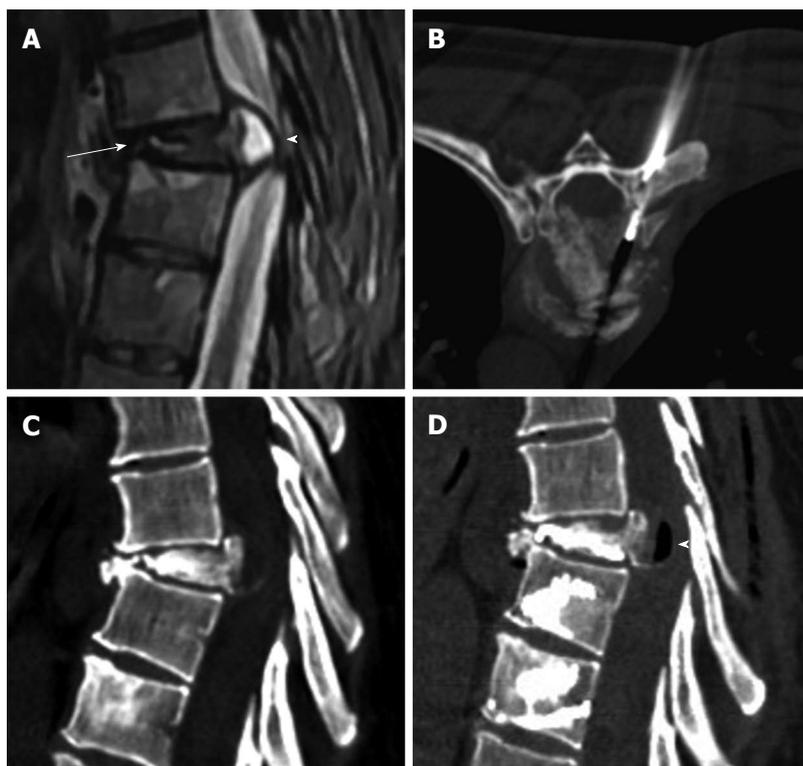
Sagittal T2 weighted (A) image shows metastatic compression fracture with intravertebral cleft (arrow) and epidural cyst (arrowhead), computed tomography guided biopsy (B), Sagittal computed tomography before (C) and after (D) vertebroplasty showing air filling of the cyst (arrowhead).
